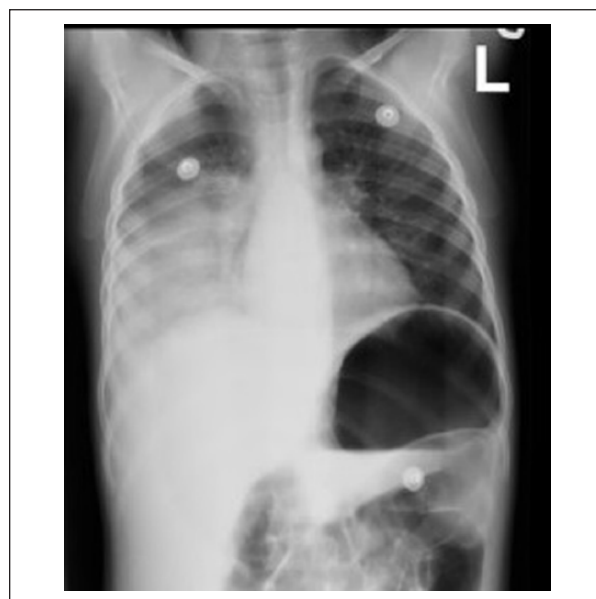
Chest X-ray at time of presentation. Note significant right parapneumonic effusion.
